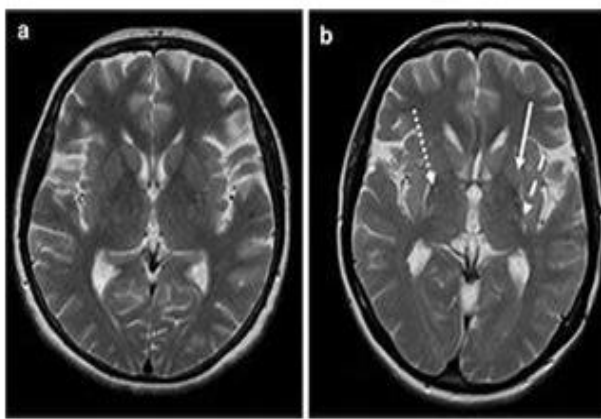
Striatal level, Axial T2 weighted MR images a) in a PD patient b) Putaminal Atrophy (arrow), Putaminal Hypointensity (dotted arrow) and Putaminal Hyperintense rim (dashed arrow) in a MSA-P patient. Adapted from [83].
